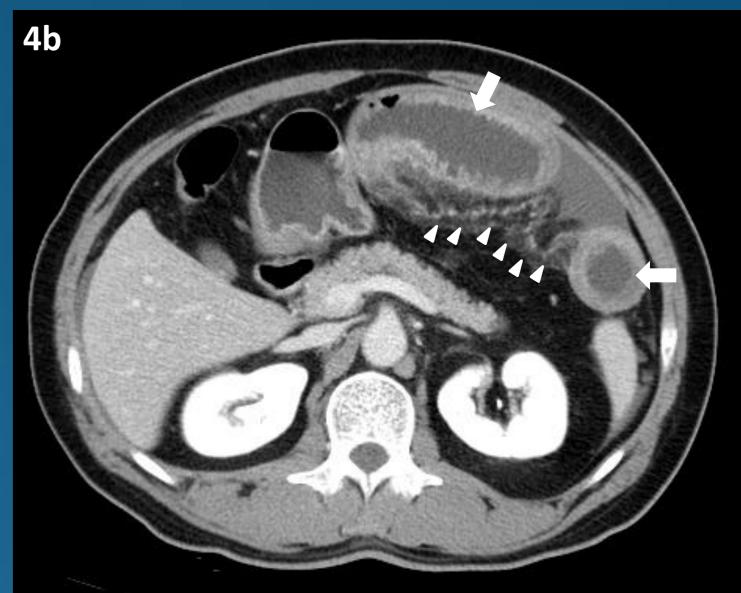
A 44-year-old man, presented with abdominal pain with nausea and vomiting due to IH, transmesenteric type. Abdominal CT in coronal (4a) and axial (4b) sections demonstrate a cluster of dilated small bowel loops in left upper abdomen, with thickened bowel wall (white arrow) and mesenteric stranding (white arrowhead). Note the narrowed afferent (Al) and efferent (El) loops were passing through the hernial orifice (O). The operation demonstrated segments of jejunum herniation through a defect at transverse mesocolon, which was then closed by suture.
